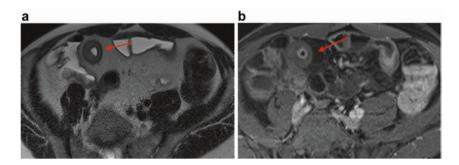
(a) Axial half-Fourier acquisition single-shot turbo spin-echo sequence demonstrates abnormal T2 signal within the bowel wall (*arrow*) signifying underlying mural edema. (b) Early (70 s) post-contrast T1-weighted image demonstrates marked wall thickening within the abnormal small bowel loop (*arrow*). We can identify the stratified wall enhancement consisting of the strongly enhancing mucosa, a poorly enhancing edematous submucosa, and an enhancing serosa
